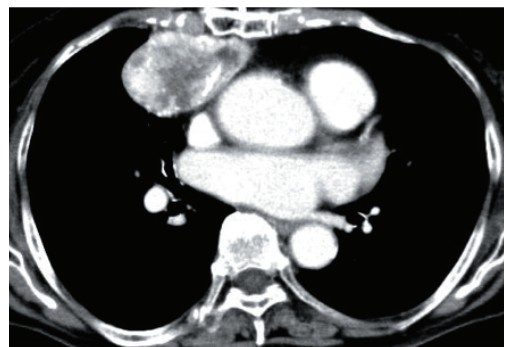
Contrast-enhanced CT image of the chest showing a large oval mass not invading the surrounding organs in the anterior mediastinum.
